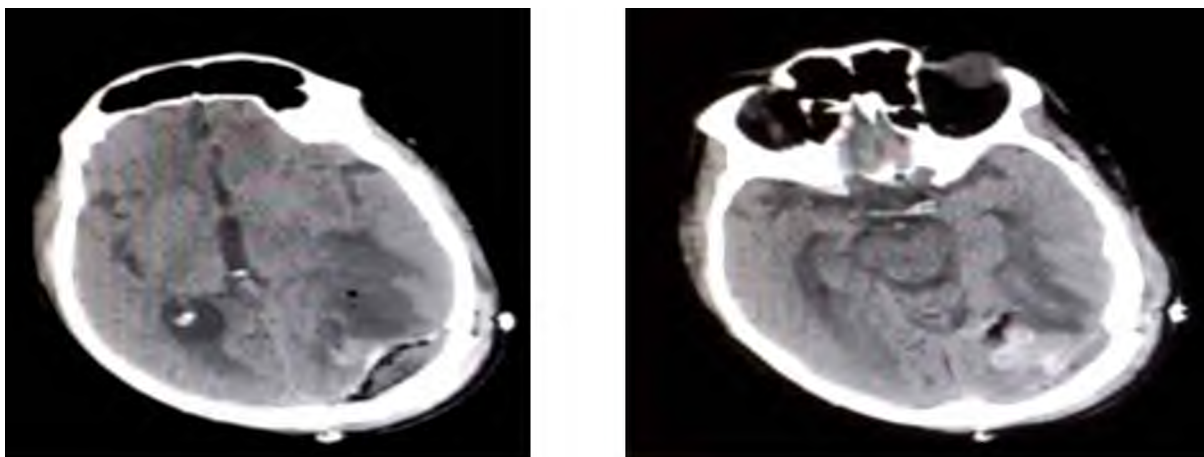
Case (1) Postoperative CT brain.
